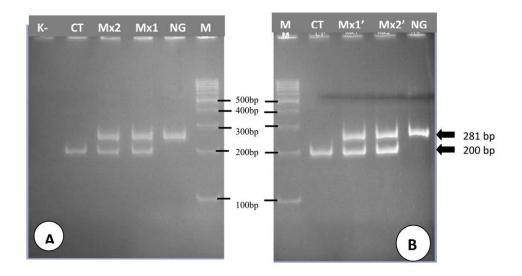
The result of amplification of *C. trachomatis* and *N. gonorrhoeae* with annealing time of 30 second (A) dan 60 second (B). M=marker 100 bp; Mx1=CTF/R 0,7μM, NGF/R 0,5μM; Mx2= CTF/R 0,6μM, NGF/R 0,5μM; CT=positive control of *C. trachomatis*; NG=positive control of *N. gonorrhoeae*
